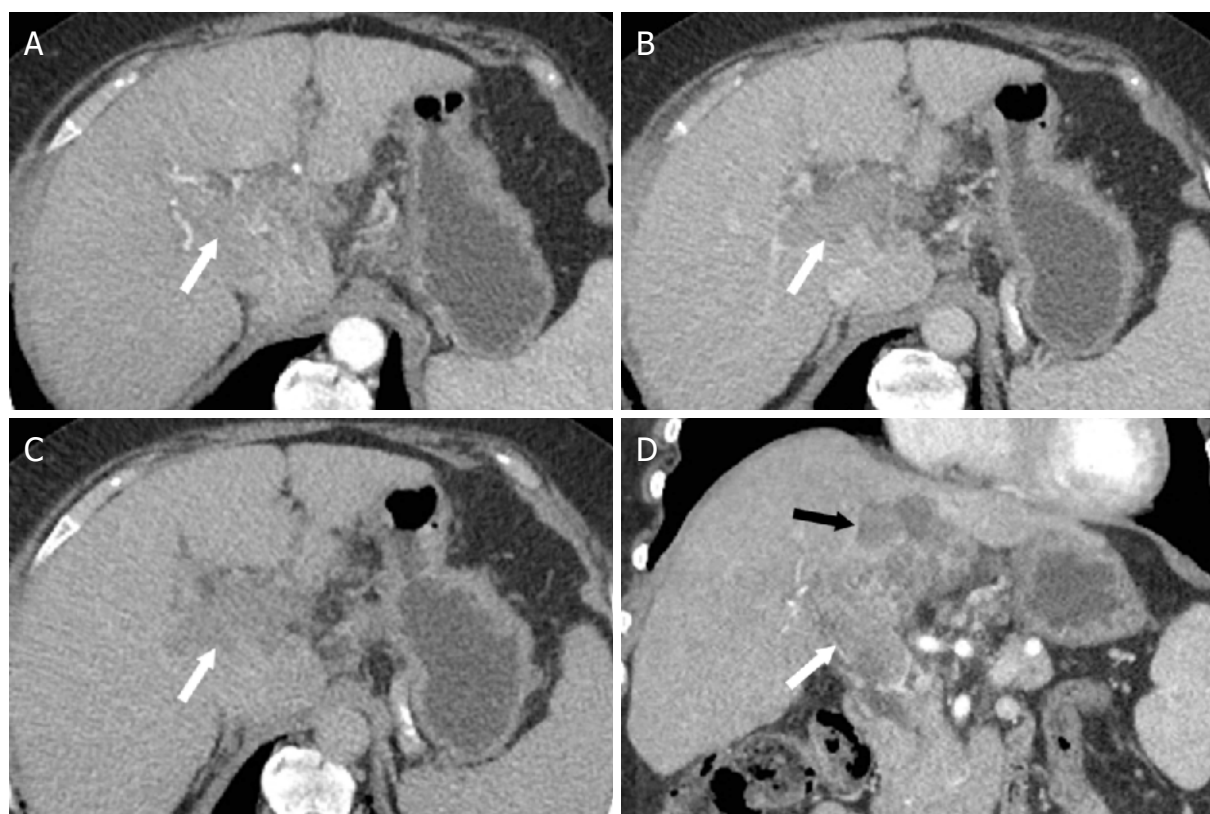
LR-TIV. Axial CT images from the hepatic arterial (A), portal venous (B), and delayed (C) phases following intravenous contrast administration and coronal image from the hepatic arterial phase (D). Enhancing soft tissue is present in the right and main portal veins (white arrow). Due to an associated parenchymal mass (black arrow) with arterial phase hyperenhancement (not shown) and “washout”, the most appropriate category for this finding is LR-TIV, likely due to HCC. CT: computed tomography; LI-RADS: Liver Imaging Reporting and Data System; HCC: hepatocellular carcinoma; LR-TIV: LI-RADS Tumor in Vein
